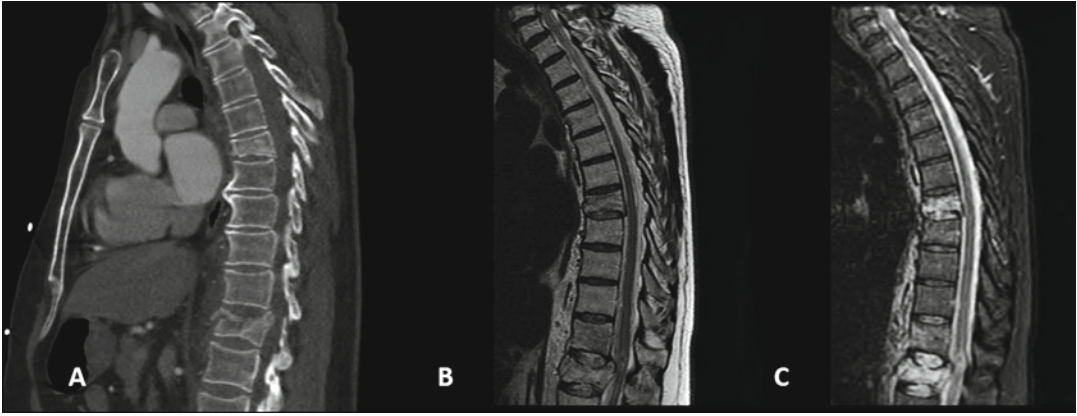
Preoperative imaging. (a) Sagittal CT. (b) Sagittal T2 MRI. (c) Sagittal STIR MRI
